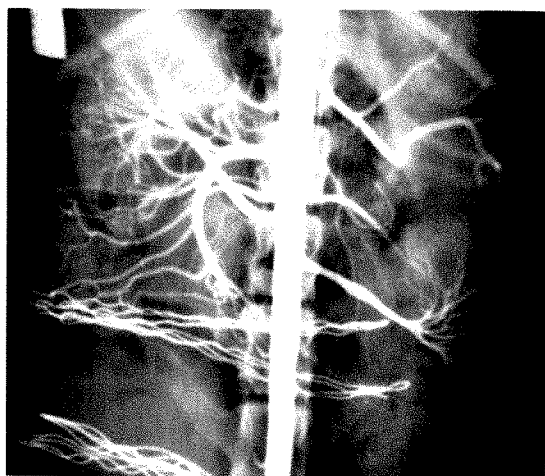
Case 1. Early study in arterial phase. Immediately prior to study an incision was made through the capsule and peripheral cortex, then deeply extended by using the handle of a scalpel to the depth of three-quarter inch. The opened plane of the injury faced the roentgen-ray beam. Little disturbance in the arterial branches is seen.
